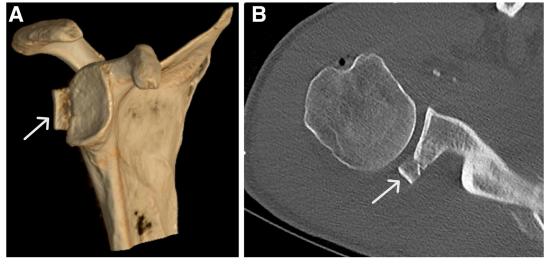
Postoperative imaging result. (A) Three-dimensional image of right glenoid. The bone block (arrow) can be seen at the posterior part of the glenoid. (B) Axial view of same computed tomography scan with bone block posteriorly (arrow).
